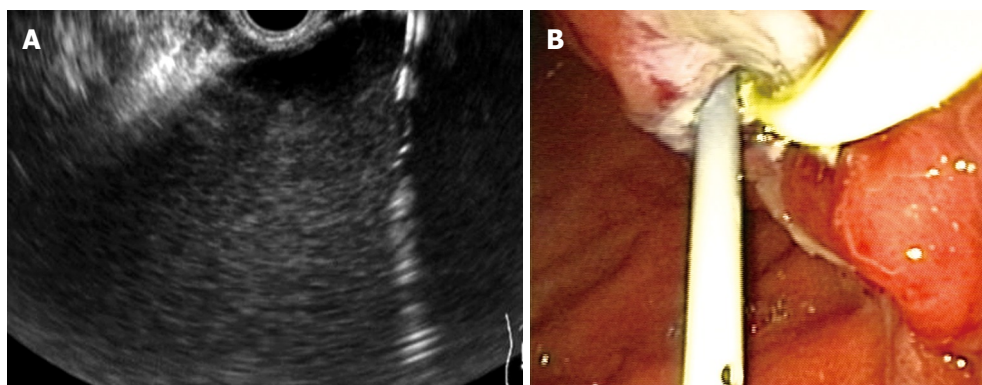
Endoscopic ultrasonography-guided pseudocyst drainage. A: The cystostomy is seen as a hyperechoic parallel structure inside the hypoechoic well-delineated pseudocyst; B: Endoscopic view of a stent and a nasocystic drainage placed transgastric into a pseudocyst.
